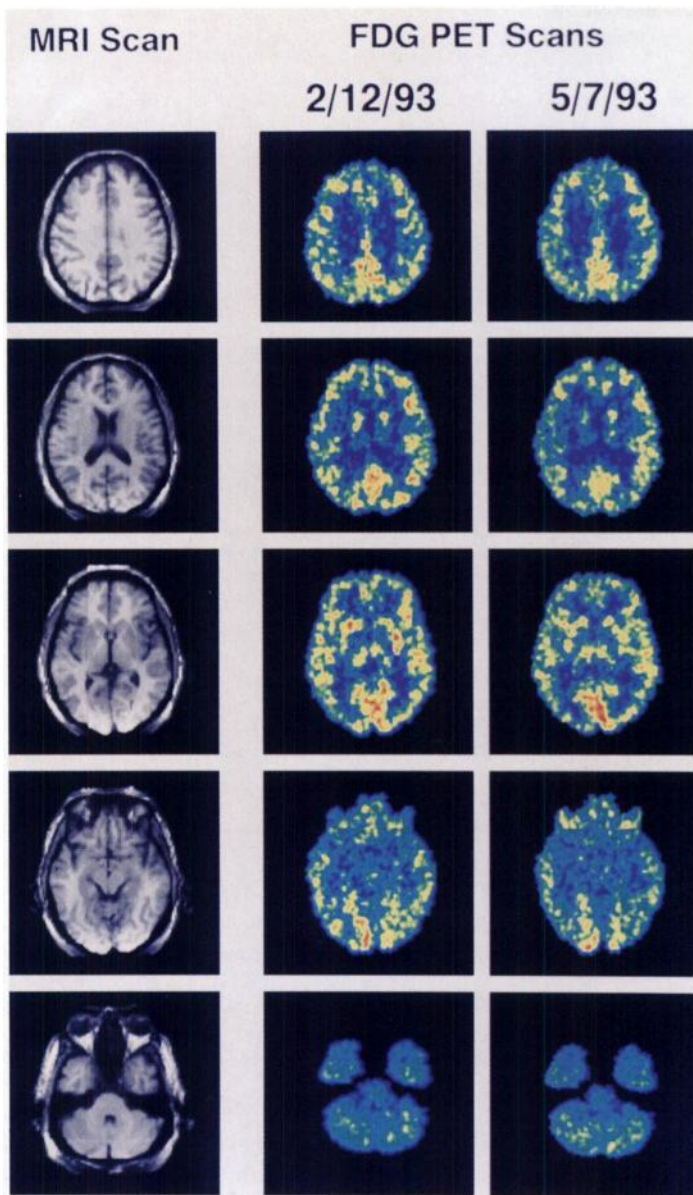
MRI and color-coded transforms of FDG-PET scans at five different levels of the brain of a representative control subject who participated in paired FDG-PET scans 12 wk apart.
